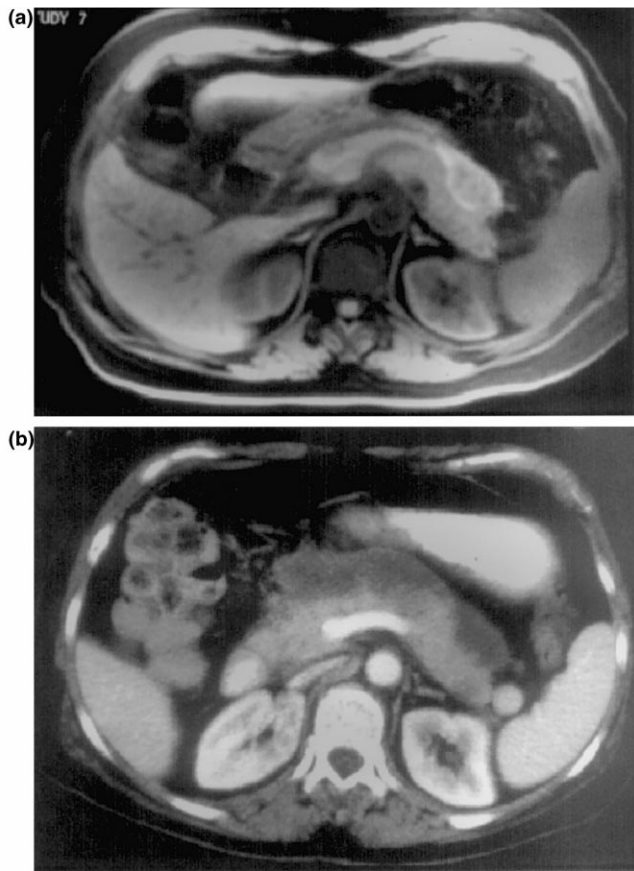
Acute pancreatitis with hemorrhage. On CT (a) image prepancreatic fluid collection is visualized, which is hyperintense on T1-weighted fat saturated MR image (b) consistent with subacute hemorrhage (Courtesy Professor Semelka, UNC, Chapel Hill).
